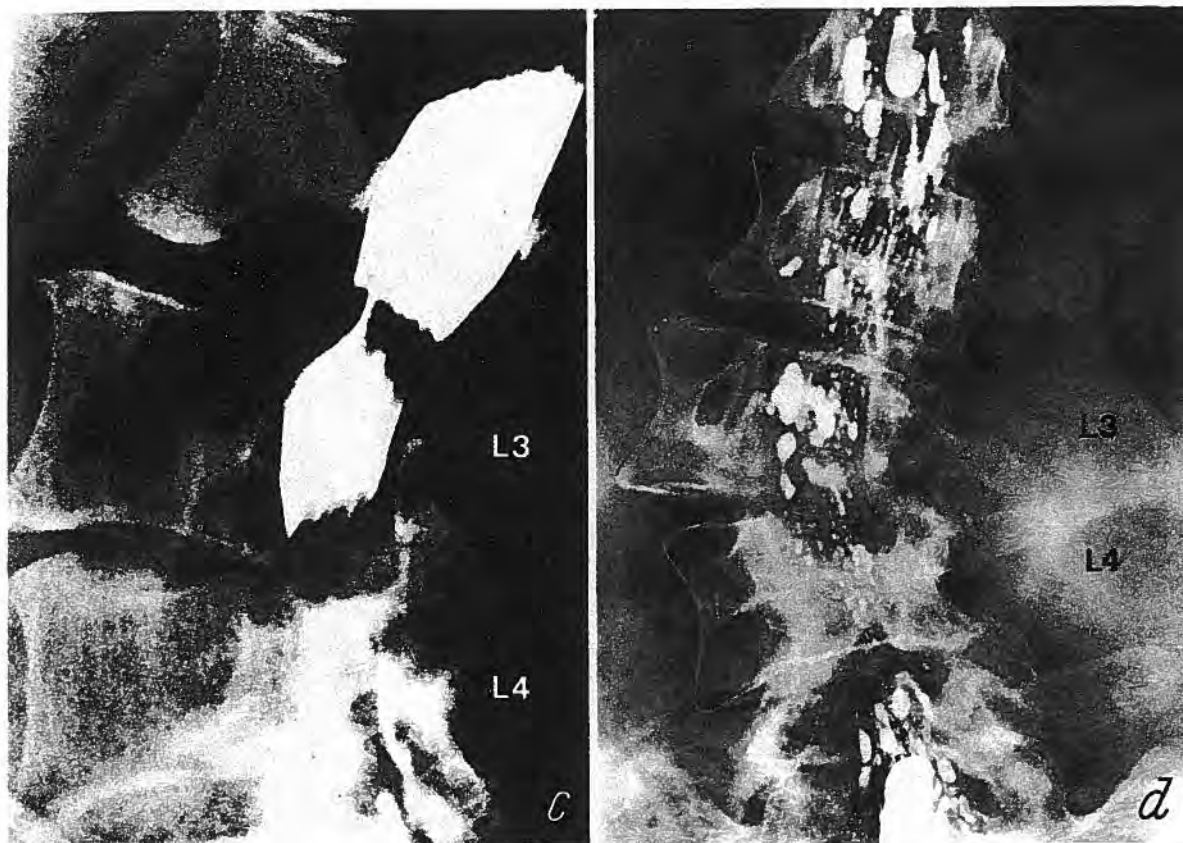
a An antero-posterior radiograph of the lumbar spine of a woman of 66 years showing congenital fusion of the vertebral bodies of L2 and L3 with resultant scoliosis, further aggravated by degenerative spondylosis at the disc between L1 and L2. This patient presented with a cauda equina claudication syndrome. b An antero-posterior radiograph of a myodil myelogram showing multi-level canal stenosis, most marked at the L1/2 and L2/3 regions. This patient's symptoms were greatly relieved following two level decompression of the spinal canal
